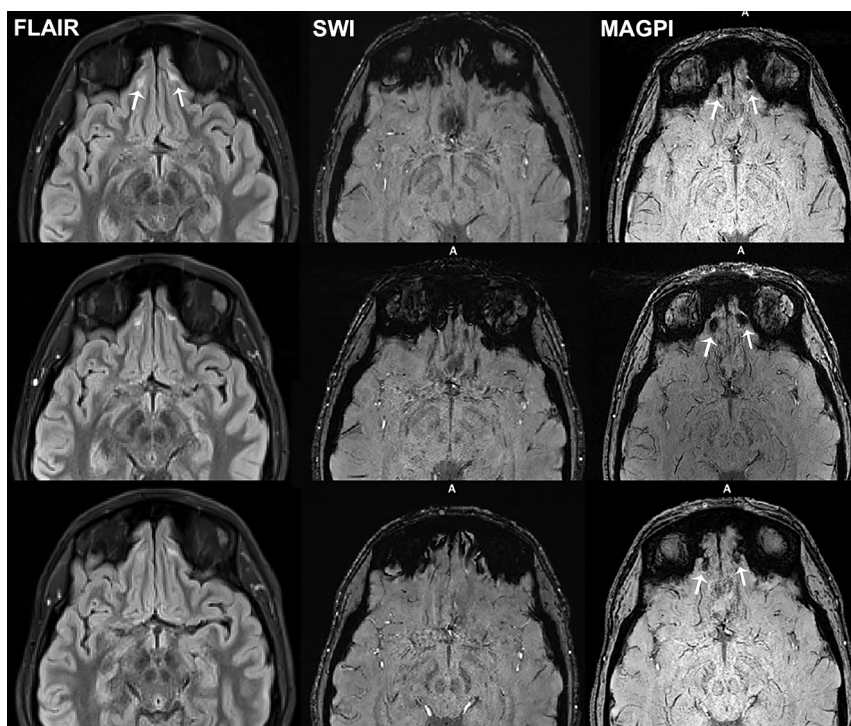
A softball player who had trauma to the forehead and nose (participant 2). The initial Post-Concussion Symptom Scale score was 38. MR images shown are FLAIR, SWI, and MAGPI-SWI obtained at 2 days (upper row), 2 weeks (middle row), and 6 weeks (lower row) after head trauma. There are small contusions in the inferior frontal lobes (arrows on FLAIR). In the same region, there are small foci of microbleeds on the MAGPI-SWI persistent on all 3 visits (arrows on MAGPI). The susceptibility signal on visit 3 (6 weeks after trauma) has slightly decreased. Please note that these microhemorrhages were exaggerated on the traditional SWI due to skull base-related susceptibility artifacts and thus were unnoticed. The Post-Concussion Symptom Scale score was 0 at 6-week follow-up.
